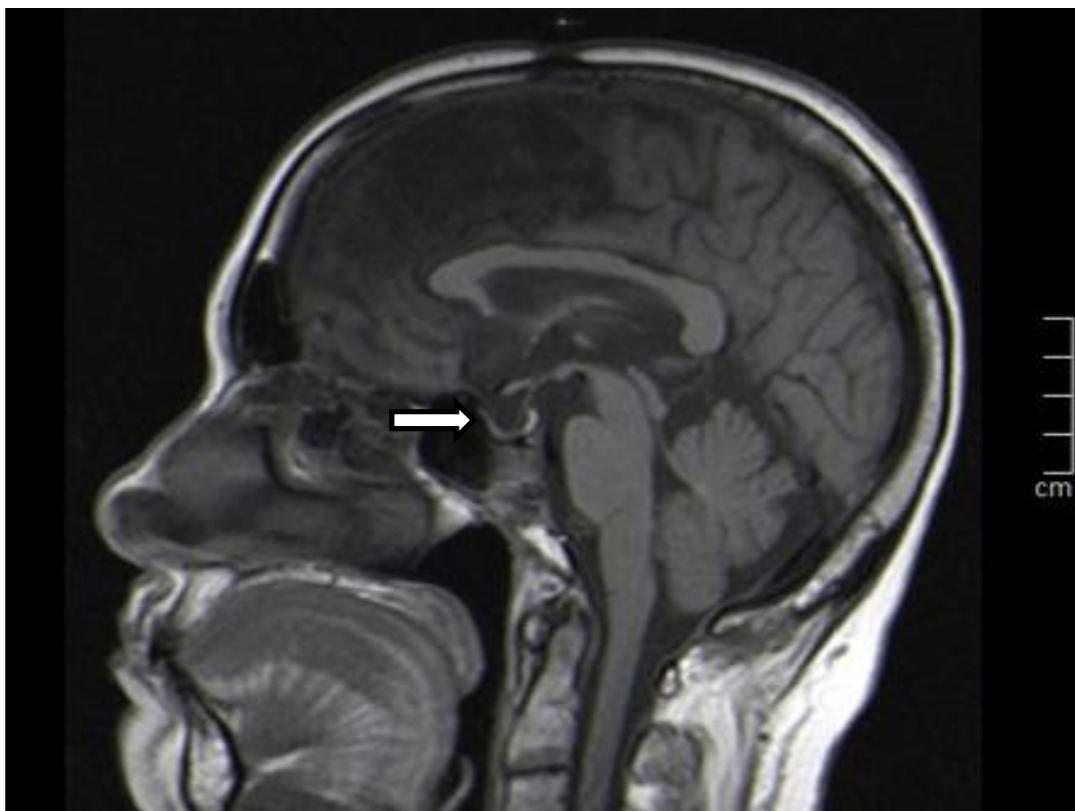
MRI Of The Brain Sagittal View Demonstrating Empty Sella.
